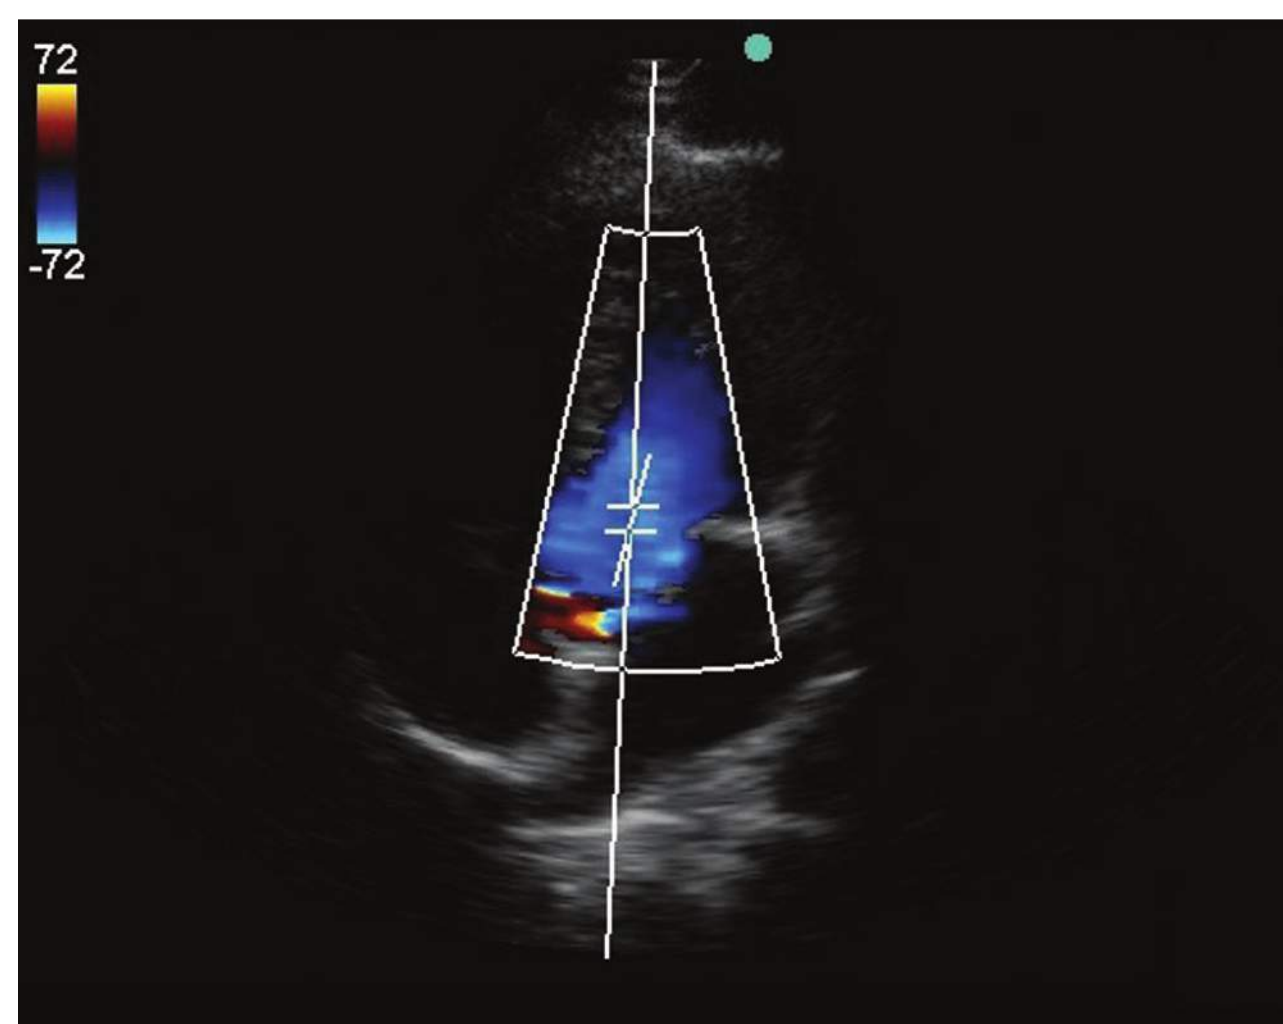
Apical five-chamber view showing the spectral Doppler gate within the left ventricular (LV) outflow tract. Note the blue color indicating flow away from the transducer and the vector adjustment of the Doppler gate to be within the LV outflow tract.
